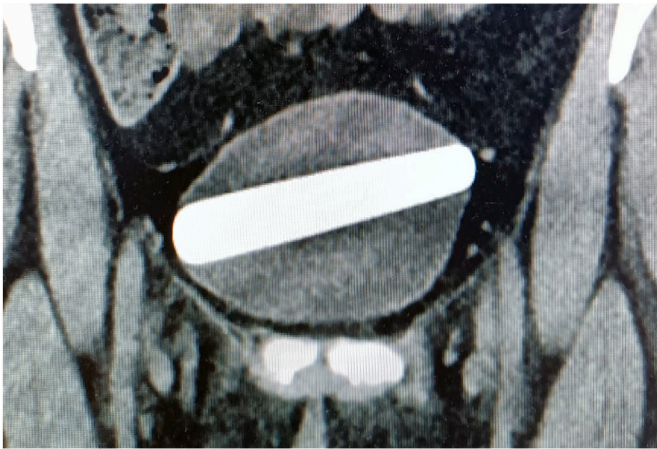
Non contrast CT scan.
